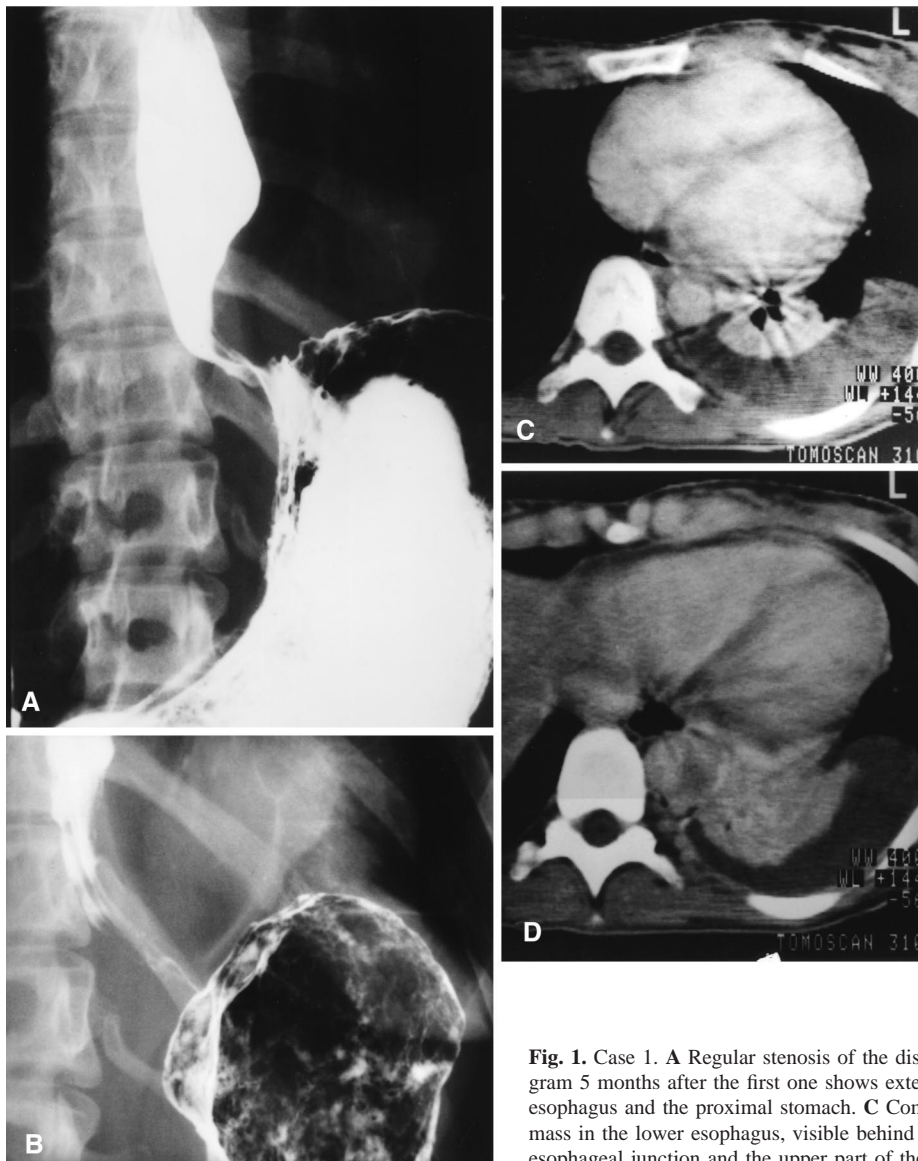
Case 1. A Regular stenosis of the distal esophagus. B Second esophagogram 5 months after the first one shows extending luminal stenosis of the lower esophagus and the proximal stomach. C Computed tomography shows a dense mass in the lower esophagus, visible behind the heart. D Mass in the gastro-esophageal junction and the upper part of the stomach.
